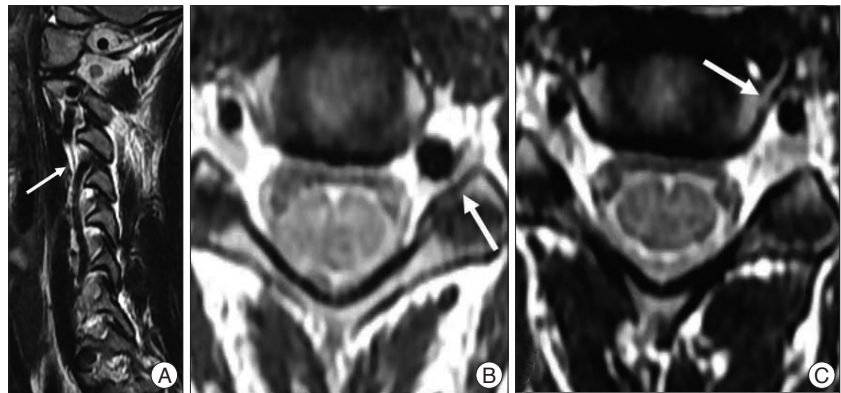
Medial loop of vertebral artery on MRI scans. T2-weight sagittal MRI section shows a disappearance of vertebral artery at the level of the C3-4 foramen (white arrow) (A). T2-weight axial MRI scans show a abnormal position of the vertebral artery leading to compressing of the left C4 root at the level of the C3-4 foramen (white arrow) (B) and normal position of vertebral artery at the level of the C4-5 foramen (white arrow) (C).
